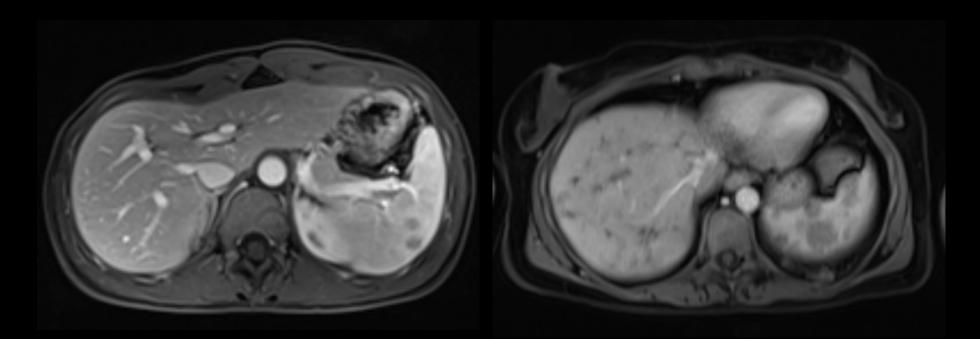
MRI, T1-wheighted images with contrast (portal phase). Focal spleen hypointense and hypoenhancing lesions.
